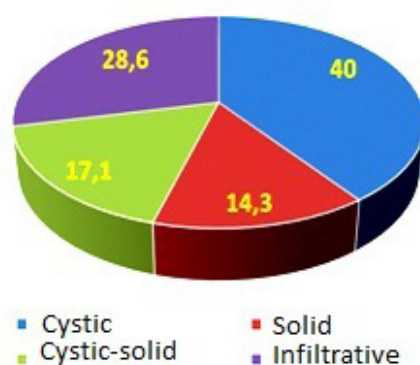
CT and MRI depending on tumor structure
